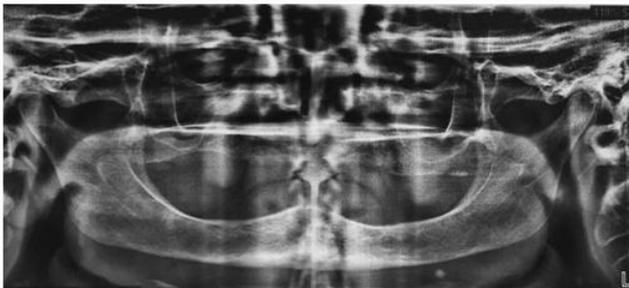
Orthopantomography (OPG) was taken for the patient and showed no osseous involvement.
